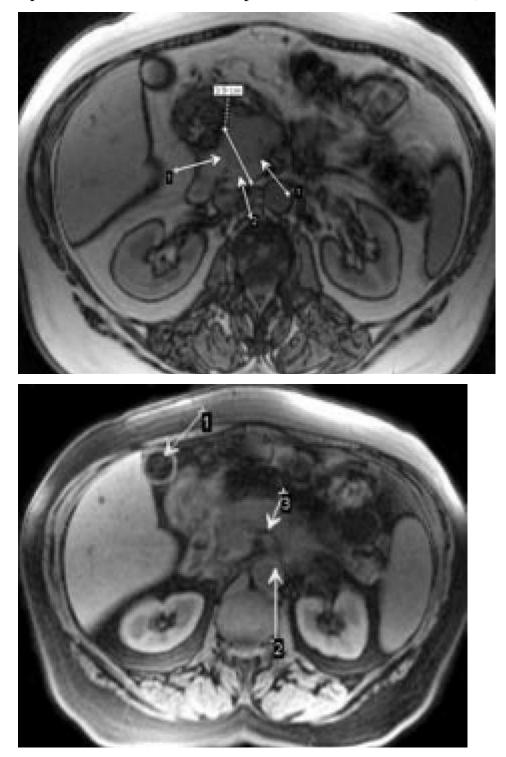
MRI of patient M., 57 years old, clinical diagnosis of CP. Aimed at examination after an attack of biliary colic, chronic pain in the upper abdomen: *a*
